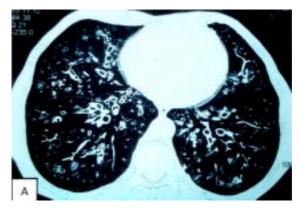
HRCT chest showing diffuse bronchiectasis and centrilobular nodules involving lower lobes.
